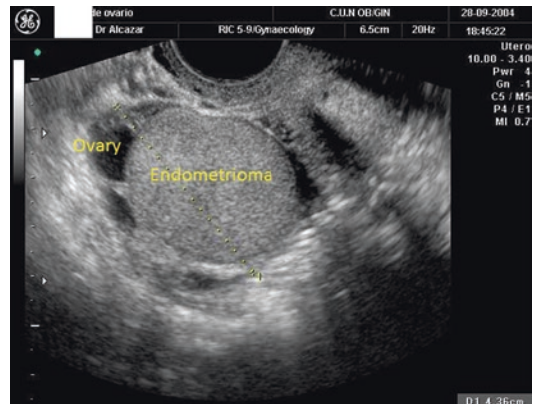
Transvaginal ultrasound showing an ovarian endometrioma with apparent solid echogenicity
